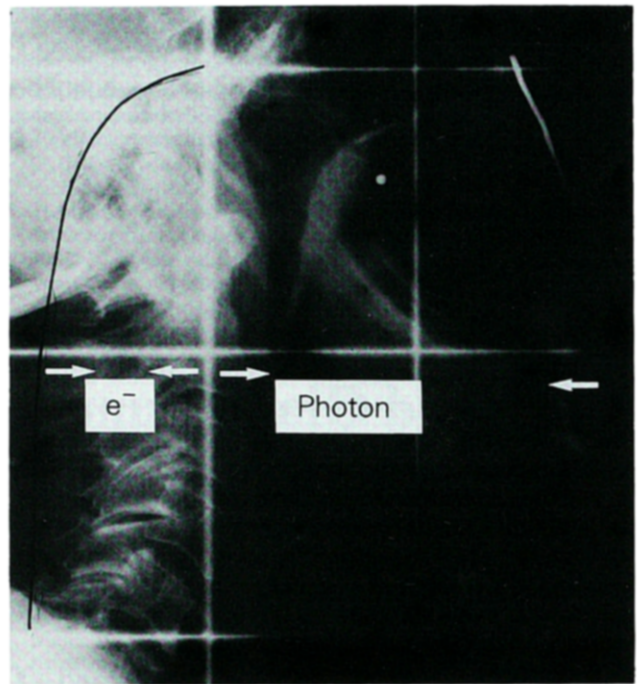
Radiographic demonstration of a treatment field demonstrating the use of combining electrons ( $e^-$ ) and photons in order to protect the spinal cord. This patient treated with 65 Gy displayed a recovery of the parotid secretion.
